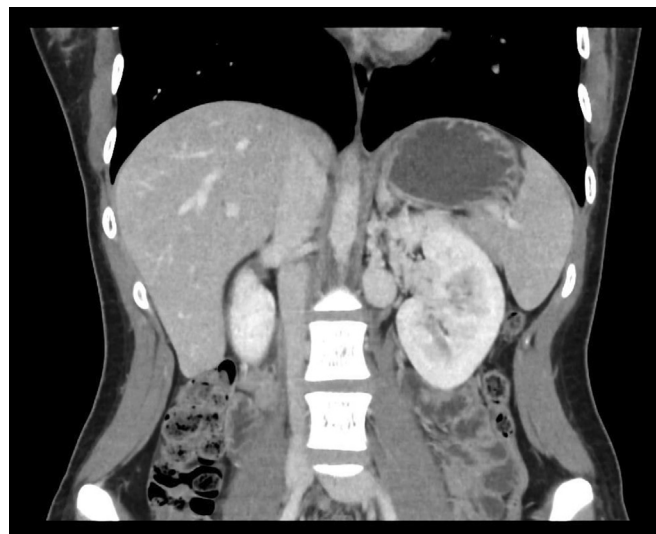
Preoperative computed tomography (CT) angiogram demonstrating extrinsic compression of the left renal vein (LRV) between the aorta and superior mesenteric artery (SMA).
